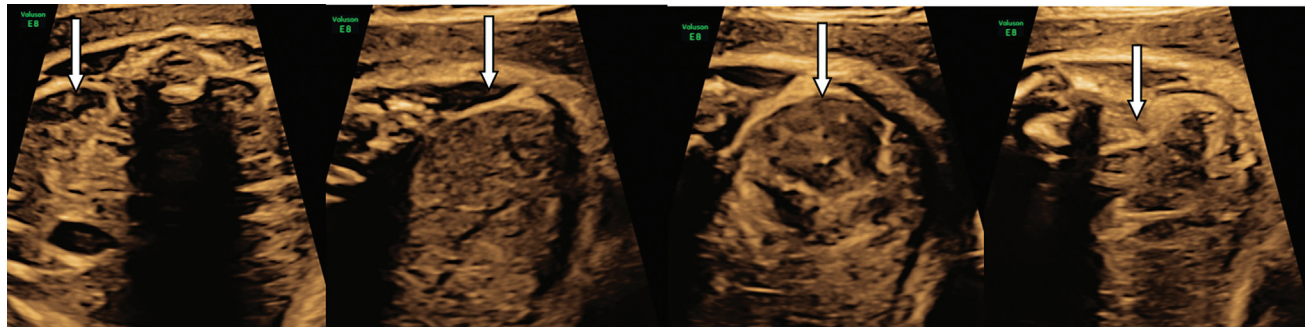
Antenatal ultrasound at 28 weeks of gestation showing both the kidneys with lack of corticomedullary differentiation, with normal amniotic fluid at 28 weeks.
